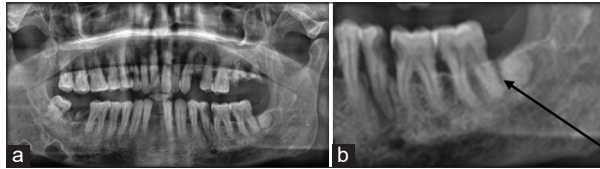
(a) Orthopantomogram (OPG); (b) OPG showing odontome (case 4)
